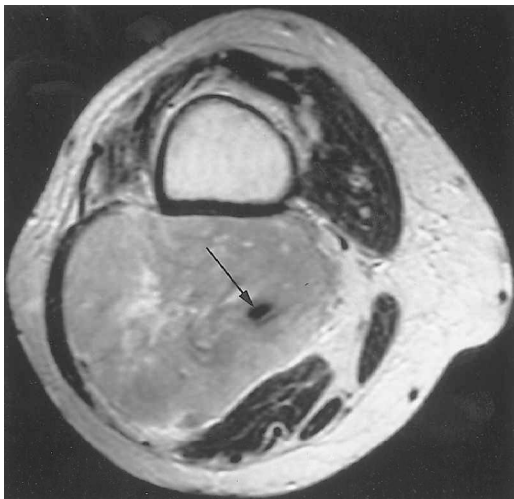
Vascular displacement and direct contact with tumor, but no encasement: (a) contrast-enhanced CT scan and (b) proton density-weighted (2466/20) MR image. The large soft tissue mass due to osteogenic sarcoma of the distal femur is in intimate contact with the popliteal artery (long arrow) and vein (short arrow); no tissue plane is evident between the mass and the vessels. Although both CT and MRI were interpreted as showing encasement of the vessels, none was present at surgery.
